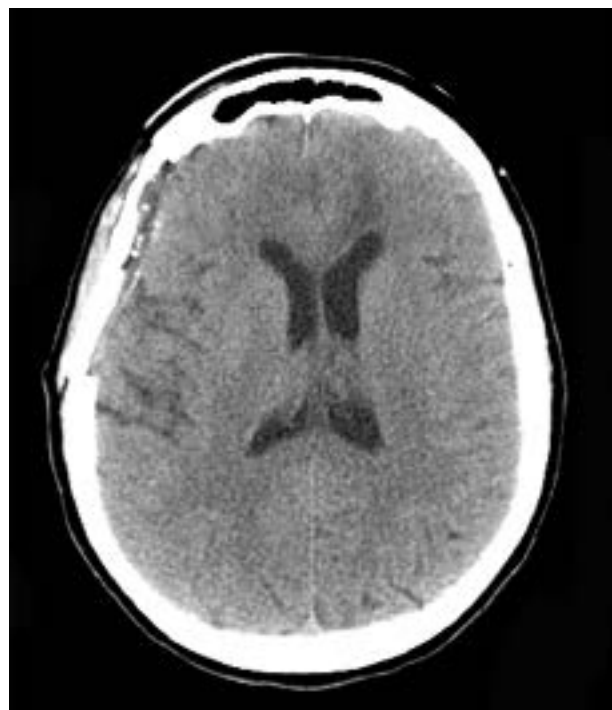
Post-infusion CT Scan: No Ischemia
